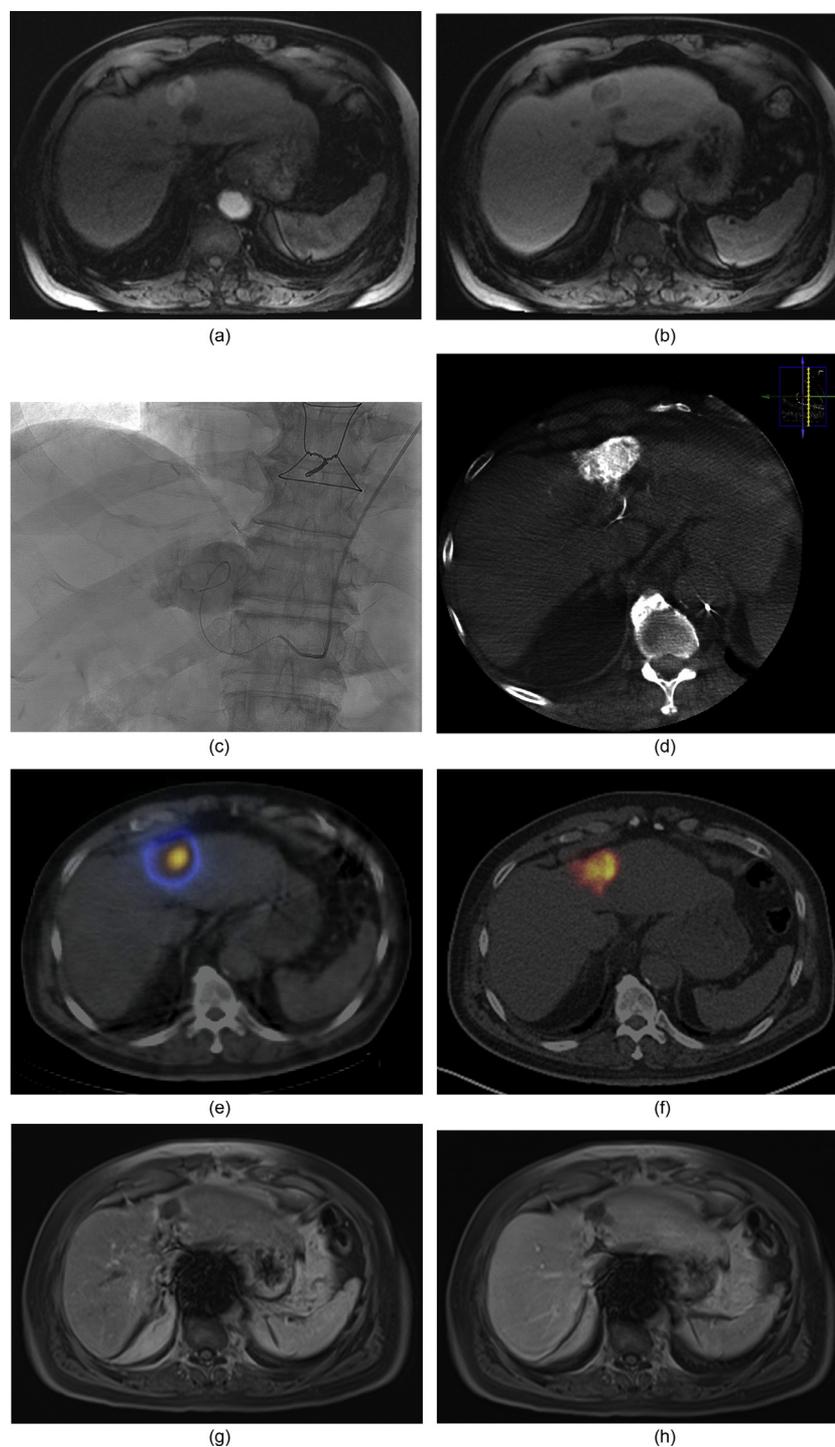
Radiation Segmentectomy. Axial T1-weighted postcontrast images obtained in the arterial (a) and venous (b) phases demonstrate a segment 4 HCC with early arterial enhancement and portal venous washout. Angiography (c) performed after subselection of the segment 4 hepatic artery shows a large region of tumor blush corresponding to the tumor visualized on MRI. Cone-beam CT (d) imaging obtained with an arterial contrast injection shows adequate coverage for the treatment of the patient's HCC and adjacent liver parenchyma with radiation segmentectomy. Fused bremsstrahlung and CT image (e) obtained immediately following radioembolization demonstrates that the delivered radiation dose is concentrated within the tumor. A research protocol PET/CT (f) also obtained following radioembolization further confirms the concentration of RE treatment in the segment 4 tumor. Axial T1-weighted postcontrast images obtained in the arterial (g) and venous (h) phases show no enhancement in the treated tumor consistent with a complete response; note the artifact in the region of the aorta related to an interval abdominal aortic aneurysm repair. The patient remains free of disease 21 months following radiation segmentectomy. HCC, hepatocellular carcinoma; RE, radioembolization.
